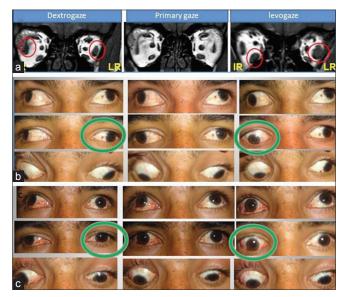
A new condition "synergistic innervational downshoot" diagnosed with the help of dynamic magnetic resonance imaging (a) magnetic resonance imaging orbit showing contraction of both right eye and left eye lateral rectus (increase in cross-section of muscle) on dextrogaze and contraction of right eye inferior rectus and left eye lateral rectus on levogaze, (b) preoperative nine gaze clinical photograph, (c) postoperative nine gaze clinical photograph
